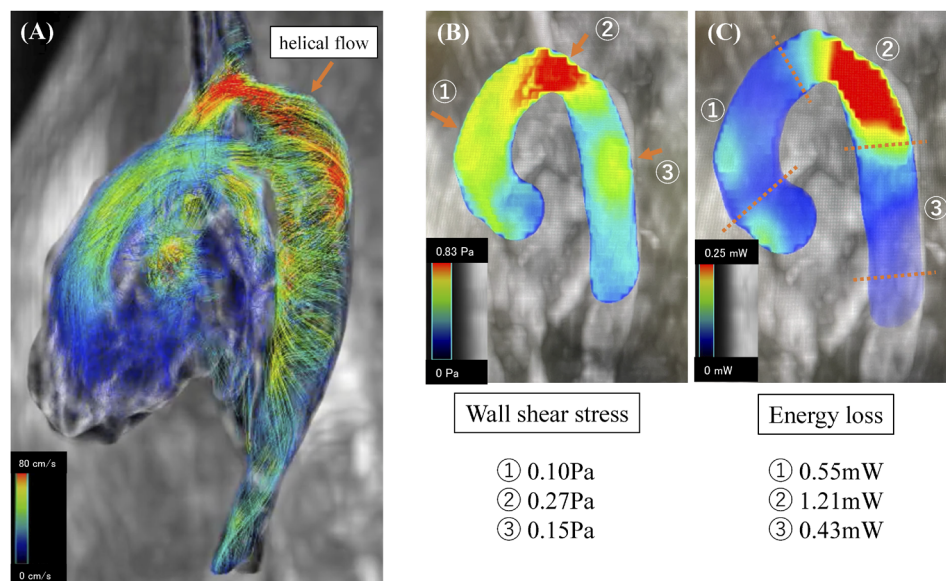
(A) Four-dimensional flow magnetic resonance imaging showed marked helical flow in the descending thoracic aorta. (B, C) Averaged wall shear stress and peak energy loss at the anastomotic site were elevated compared to those in the ascending and the descending aorta.
